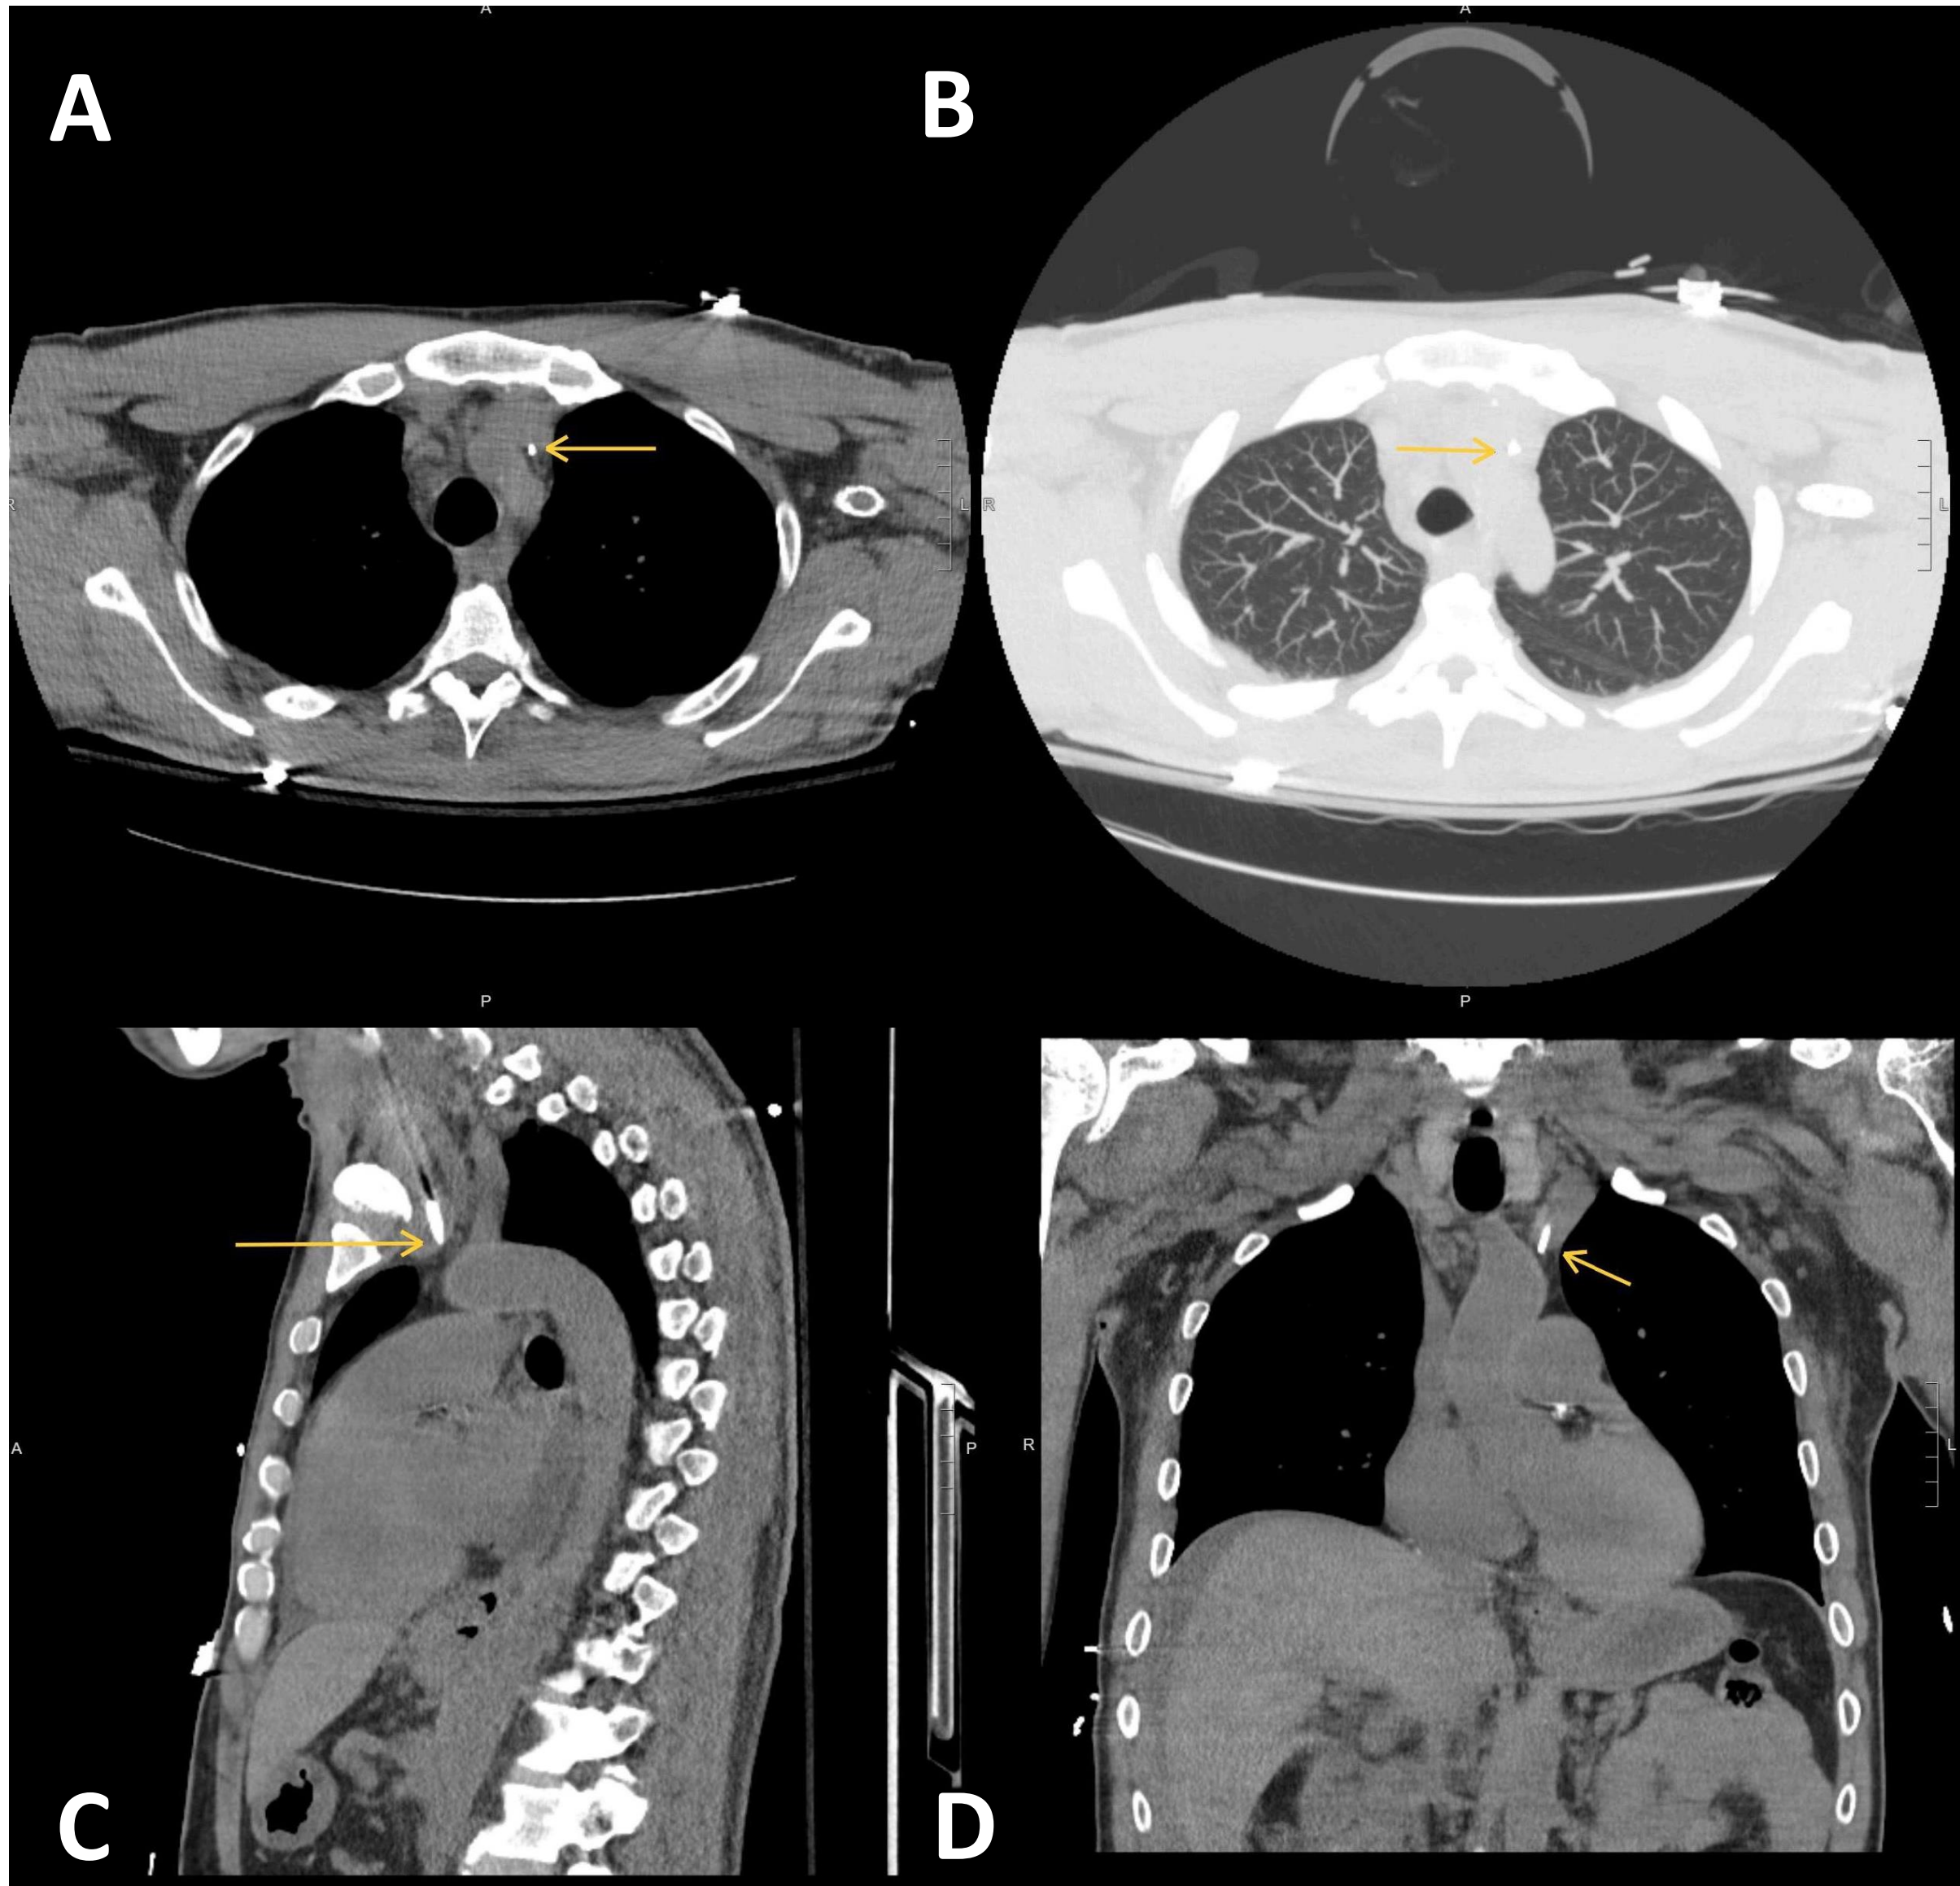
Multiplanar CT confirming venous placement in the left brachiocephalic vein
